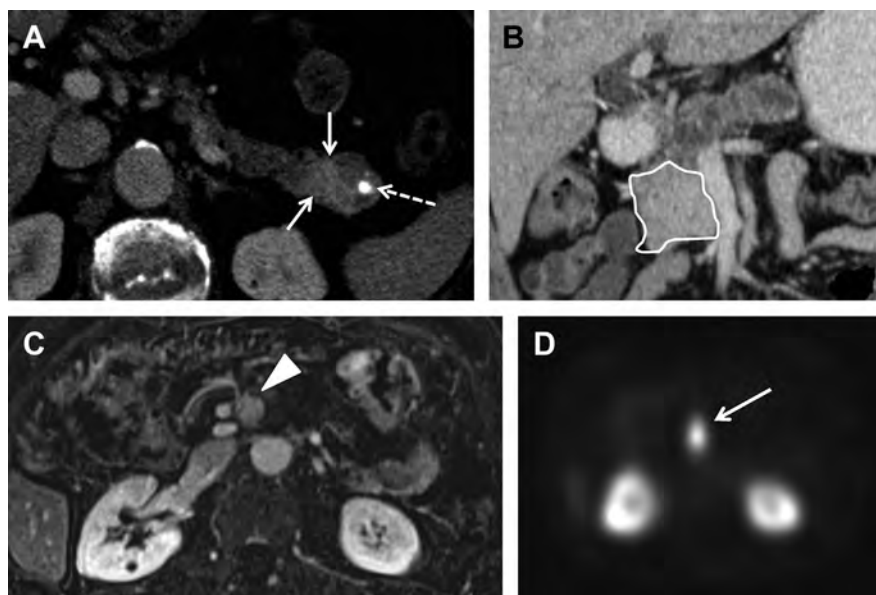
Axial contrast-enhanced CT scan shows pancreatic tail PNET that is hypervascular (*solid arrows*) compared with the background pancreas (*A*). The mass contains a calcification (*dashed arrow*). Axial contrast-enhanced CT scan in another patient with pancreatic head PNET enhancing more than the background pancreas (*outline*) (*B*). Axial T1 contrast-enhanced MRI in a patient who had undergone pancreaticoduodenectomy for pancreatic head PNET with new enhancing soft tissue nodule adjacent to the superior mesenteric artery (*arrowhead*) (*C*). Axial image from IN-111 octreotide study in the same patient at the same level shows that the nodule takes up octreotide (*arrow*), compatible with recurrent/metastatic disease (*D*).
